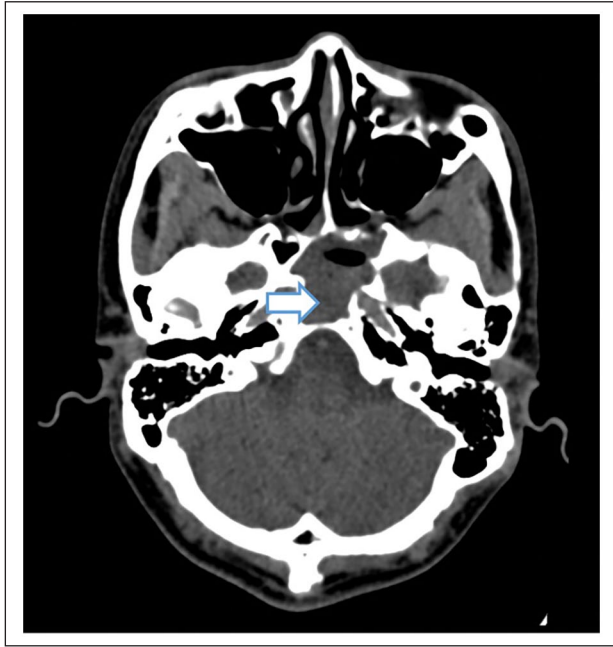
Axial slice CT paranasal sinus at the level of sphenoid sinus with white arrow showing mucosal thickening within the dominant left sphenoid sinus.
